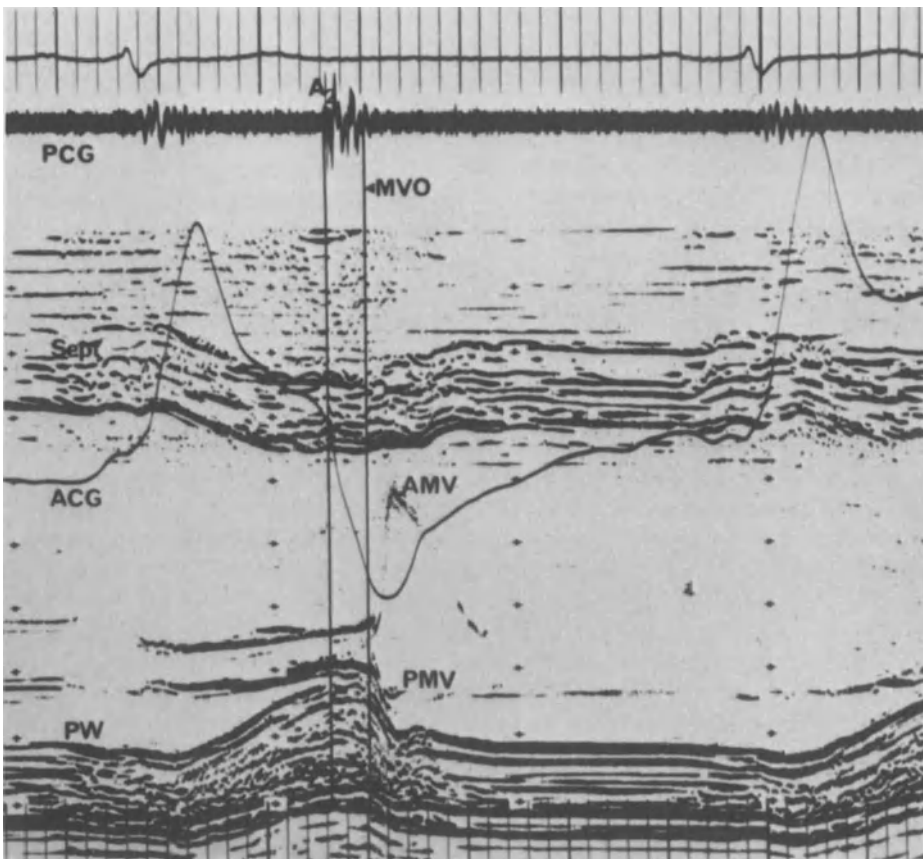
M-mode echocardiography recording
